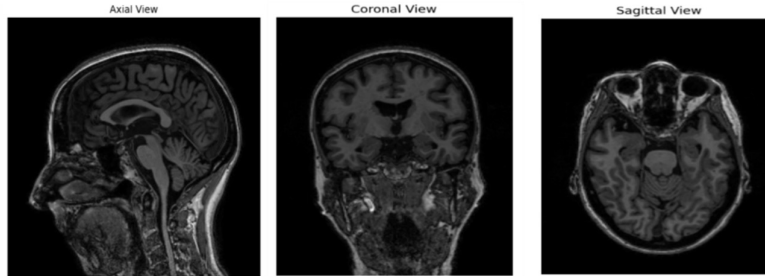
Representative brain MRI slices in axial, coronal, and sagittal planes.
